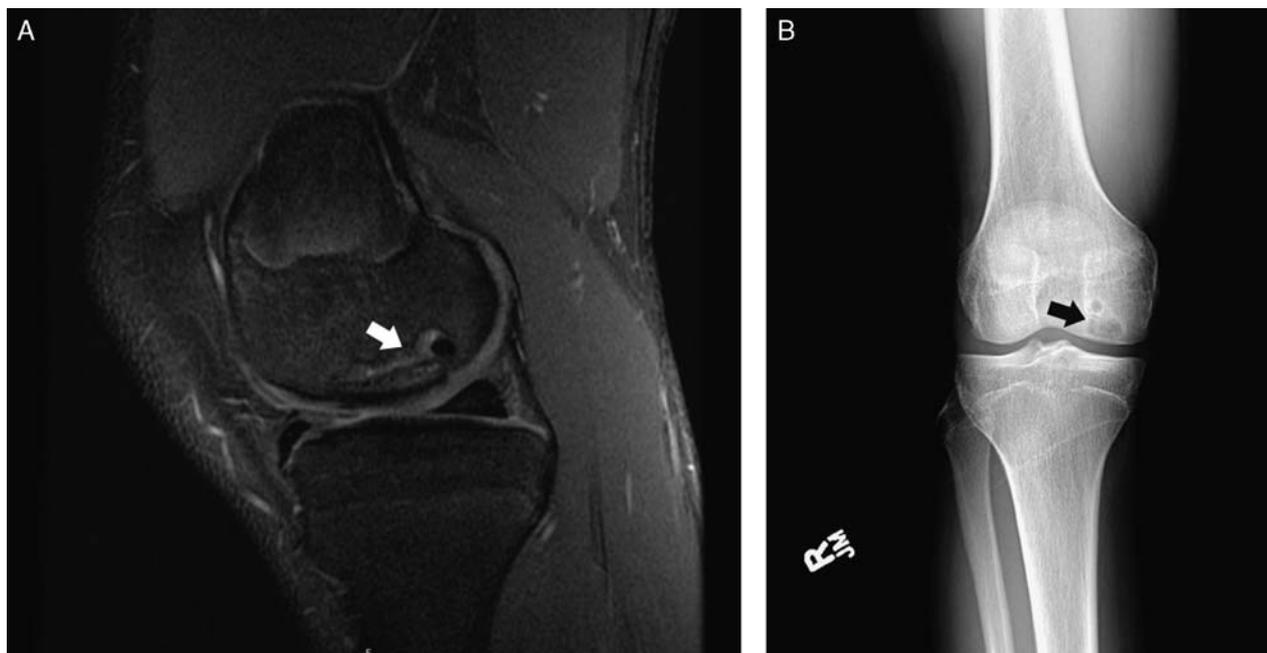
Anteroposterior radiograph (B), sagittal proton density magnetic resonance imaging (A) demonstrating osteochondritis dissecans lesion (arrows) of the medial femoral condyle with cystic changes in a 17-year-old boy.
